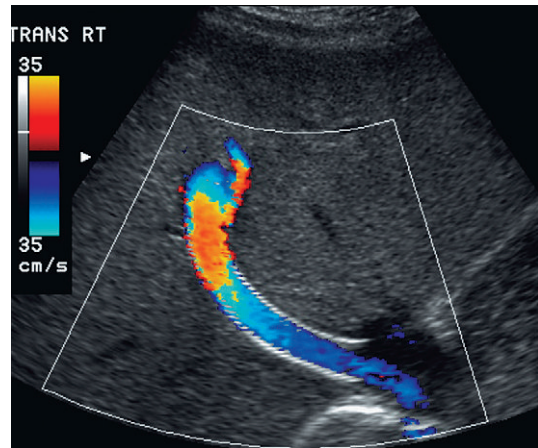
Oblique colour Doppler image of the TIPS. The entire lumen is saturated with colour indicating patency. Note the non-uniformity of colour encoding – a function of narrowing at the area of stent overlap.
